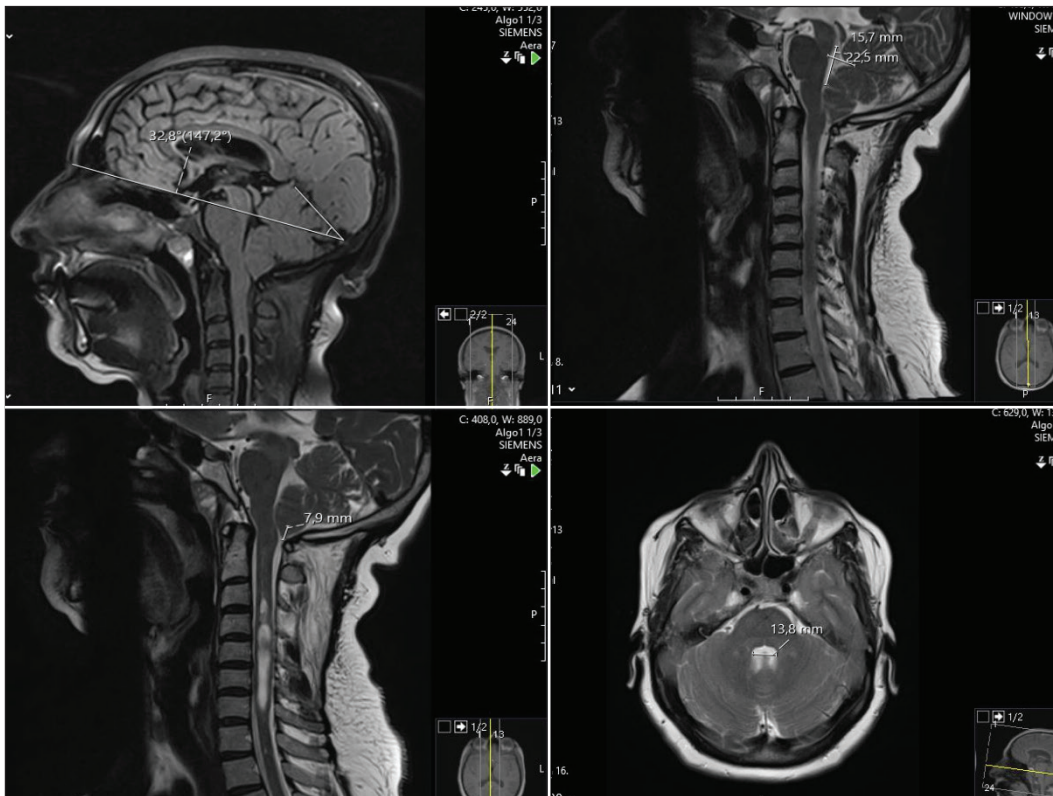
Measurements on magnetic resonance imaging sequences in patients with Chiari type 1 malformation.
